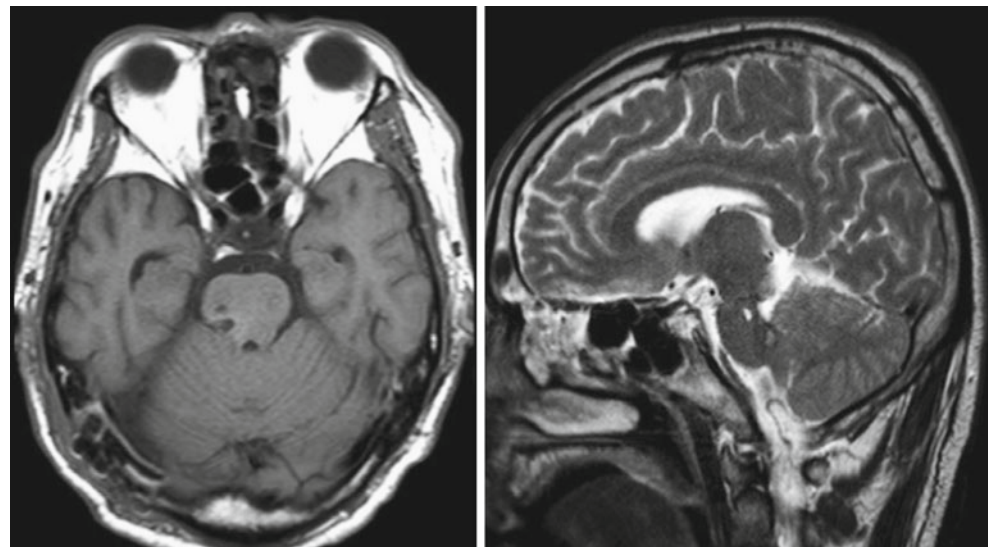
Post-operative MRI showing total removal of the lesion
